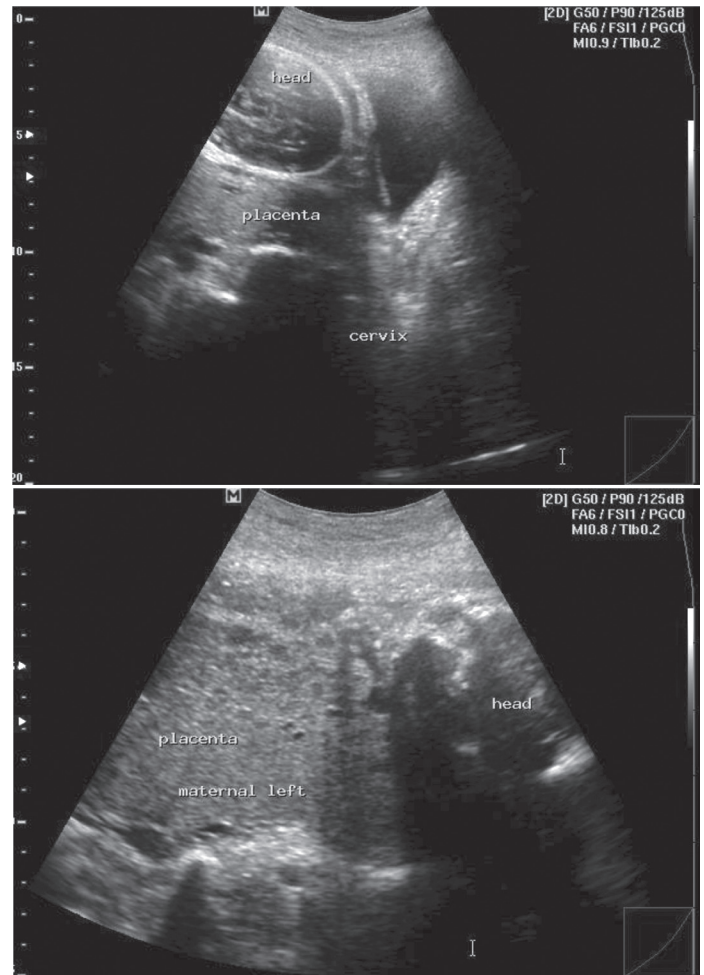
Ultrasound at 25 weeks age of gestation: Placentomegaly and placental previa Totalis; Consider a partial mole, rule out twin gestation with a singleton fetus and hydatidiform mole.
